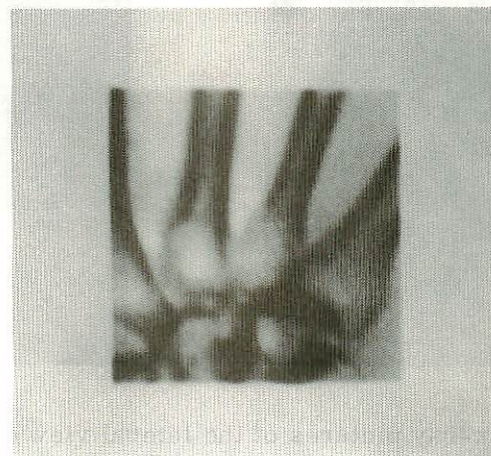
Scanned x-ray pictures of a model of a hand by use of the scan converter tube and the TV monitor (local sweep). (a): A scan of 10 sec per frame; (b): Superposition of 10 repeated frames; (c): Enlarged image by scanning a part of the model.
